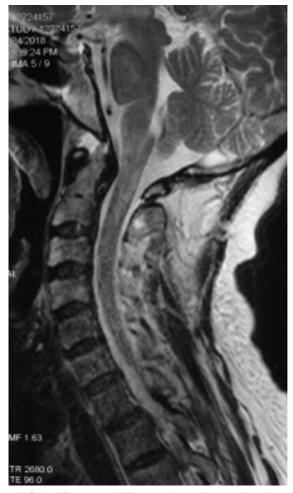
Sagittal T2-weighted MRI shows lesions from medulla oblongata to the 2nd cervical level.
